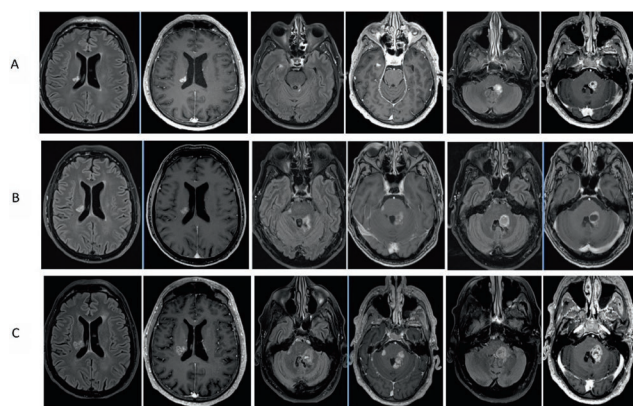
Progression within the months of the WML located in right temporal periventricular region and cerebellar peduncles. Contrast-enhanced T1 and T2-FLAIR acquired in (A) September 2023, (B) November 2023 and (C) January 2024.
